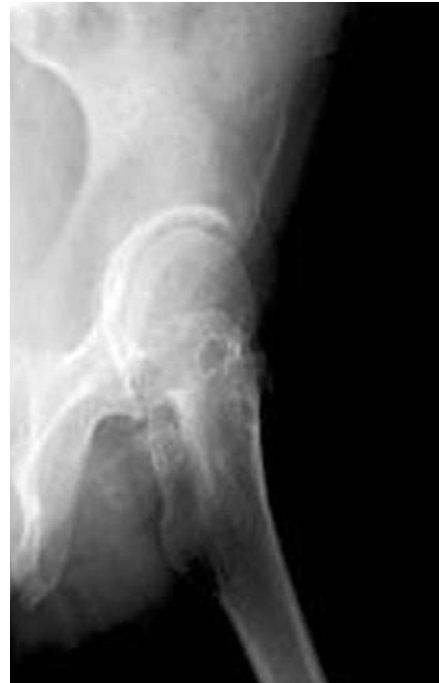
Lateral hip radiograph of a 57-year-old woman with synovial osteochondromatosis shows small faint dense loose bodies and prominent pressure erosions of the left femoral neck.
